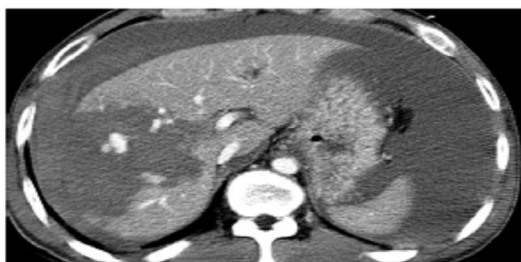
Grade IV hepatic injury. Contrast-enhanced CT scan of the died patient shows a ruptured intraparenchymal hematoma with active bleeding in the right hepatic lobe and the associated large hemoperitoneum.
